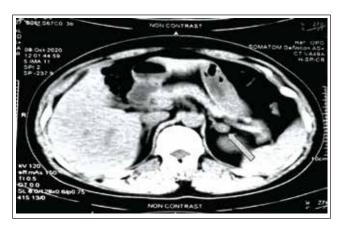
CT scan of the abdomen is showing a left-sided adrenal adenoma
